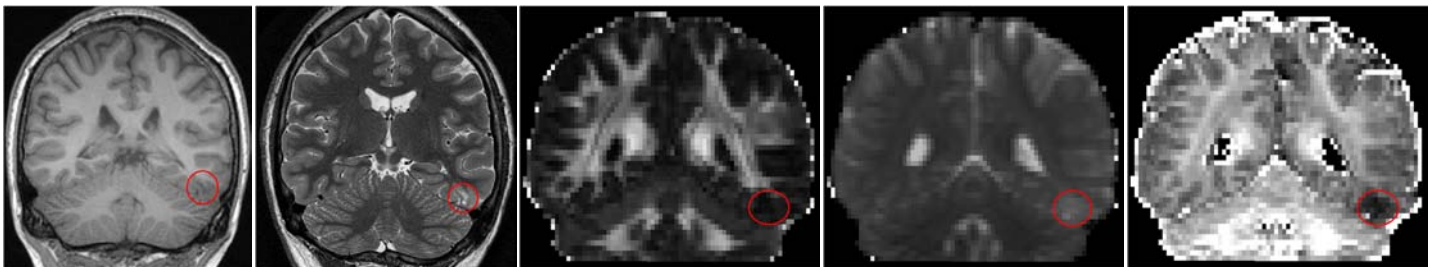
FCD poorly defined on anatomical images including T1-weighted (far left), T2-weighted PROPELLER (second from left) and hard to discern on standard DTI images including fractional anisotropy (FA, middle), mean diffusivity (MD, second from left) but easily visible as reduced intracellular volume fraction (far right)
